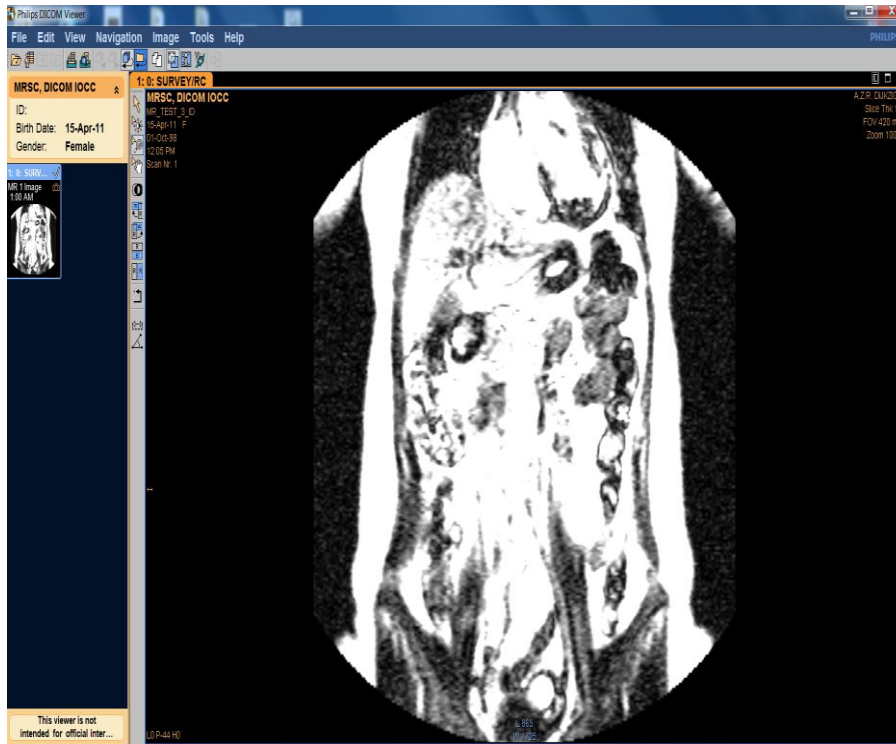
Philips DICOM viewer screen shot of image obtained from MRI Modality
